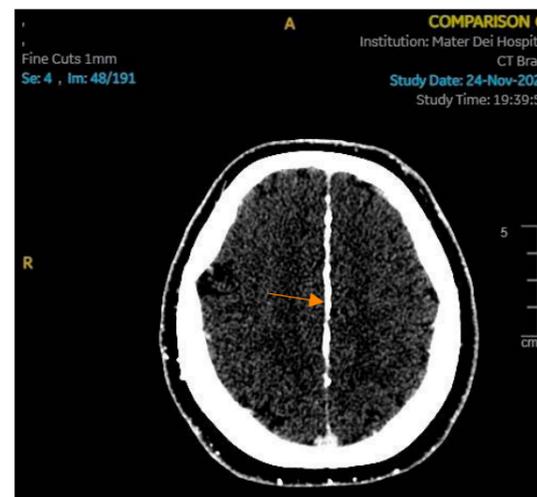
A CT scan of the brain showing calcification of the falx cerebri (arrowed)
